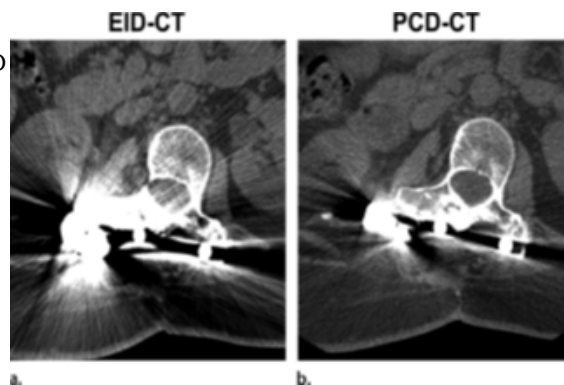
Reduction of metal artifacts at PCD CT. Axial EID (a) and PCD (b) CT images of a fused lumbar spine show that the reduction of metal artifacts arising from the posterior metallic hardware enables visualization of the spinal canal, which was obscured by the metal artifacts on (a) (Leng et al. 2019).
